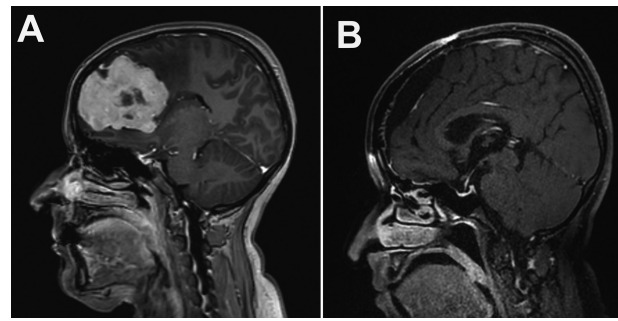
Contrast-enhanced cranial magnetic resonance imaging identified a 66cm² calcified mass in the left frontal lobe (A). When the patient's history was examined, it was found that B-cell common ALL (CALLAB) had been diagnosed and treated 10 years prior to presentation. The intraoperative mass was totally resected, and there were no complications. Remarkably, the patient's headache and visual complaints improved, and no recurrence was observed during the follow-up visit 1 year postoperatively (B).
